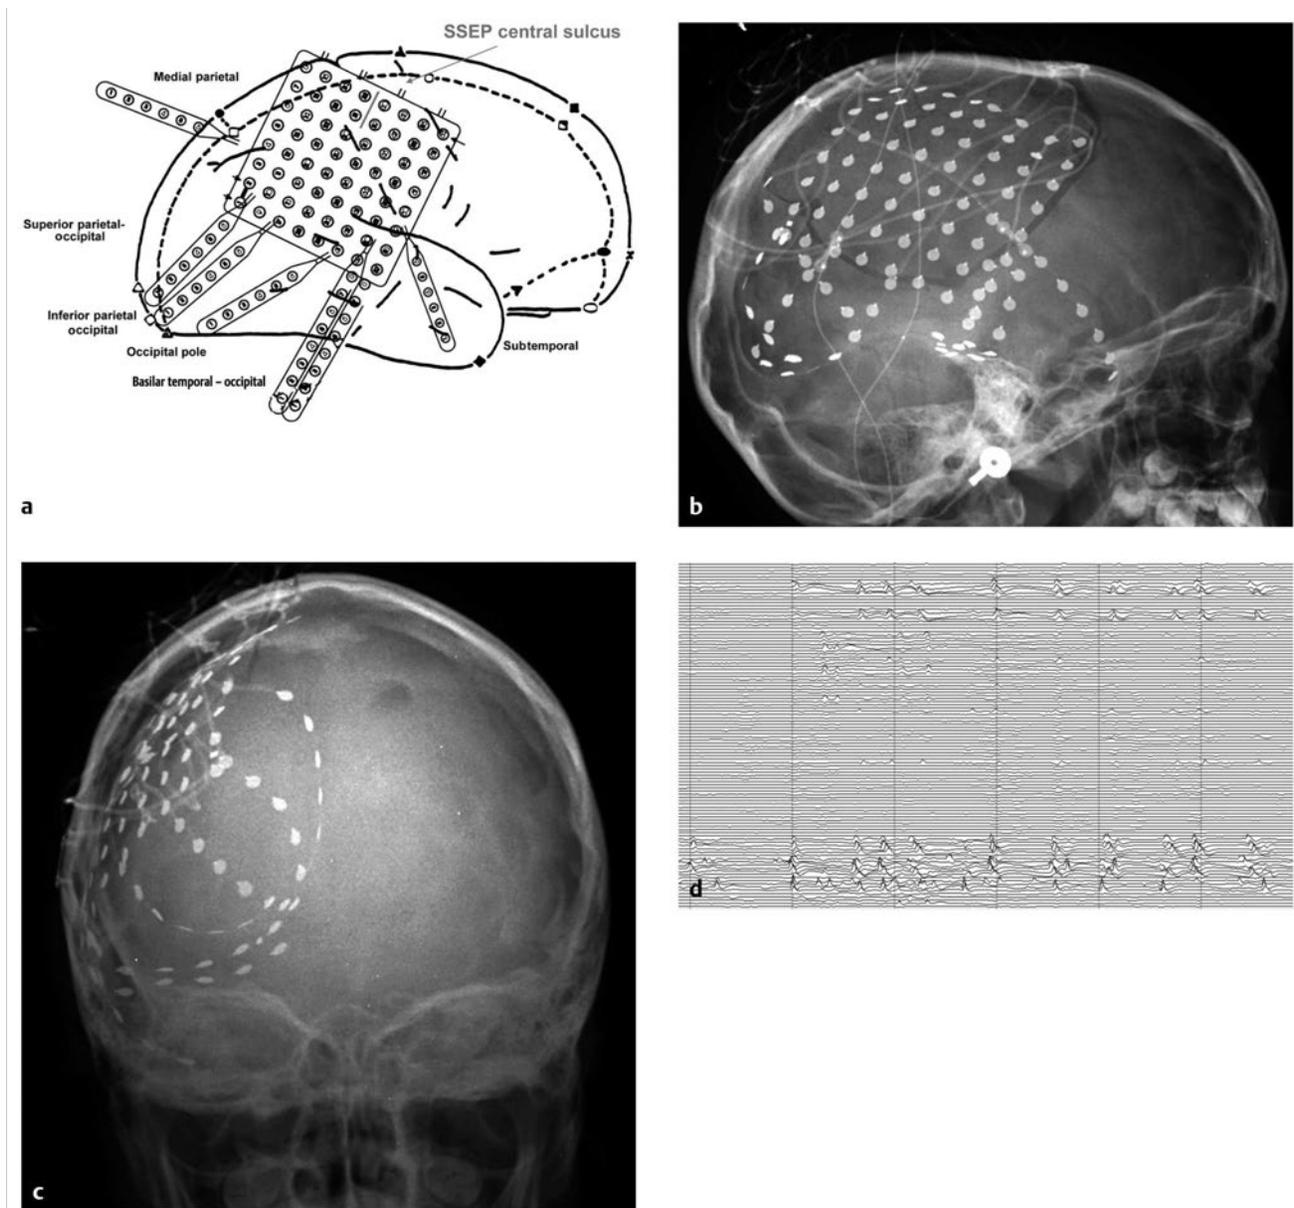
Ictal localization for a parieto-occipital resection. (a) Pictorial representation for planning the placement of the grid array with respect to the cortical surface. The 8 × 8 grid can be seen, with adjacent six-lead strip electrodes overlying various portions of the cortex. The central sulcus is marked under the overlying grid. SSEP, somatosensory evoked potential. (b) Postoperative lateral plain radiograph revealing placement of the array of grid and strip electrodes for ictal localization. The underlying craniotomy can be seen with lucency in the calvaria. (c) Postoperative anteroposterior plain radiograph revealing the same placement of the grid array and strip electrodes. (d) Electroencephalogram from placement of the grid and electrodes localizing epileptic activity with spike-wave complexes to the occipital lobe.
